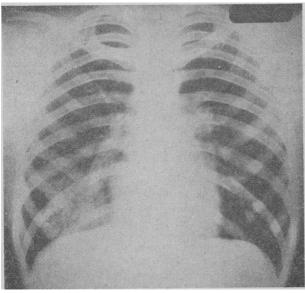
Photograph of chest x-ray film of Case 1 eight days after onset of illness, showing consolidation in right lower zone of lung
